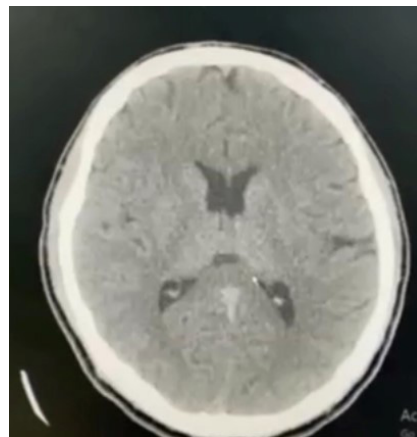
Axial view of emergency contrast enhanced CT of the brain showed no demonstrable abnormality in this study
